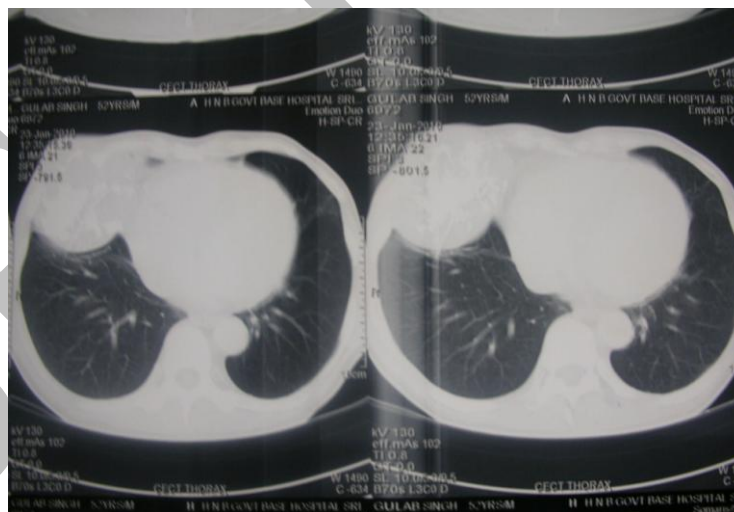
CT scan chest showing lobulated tumor
